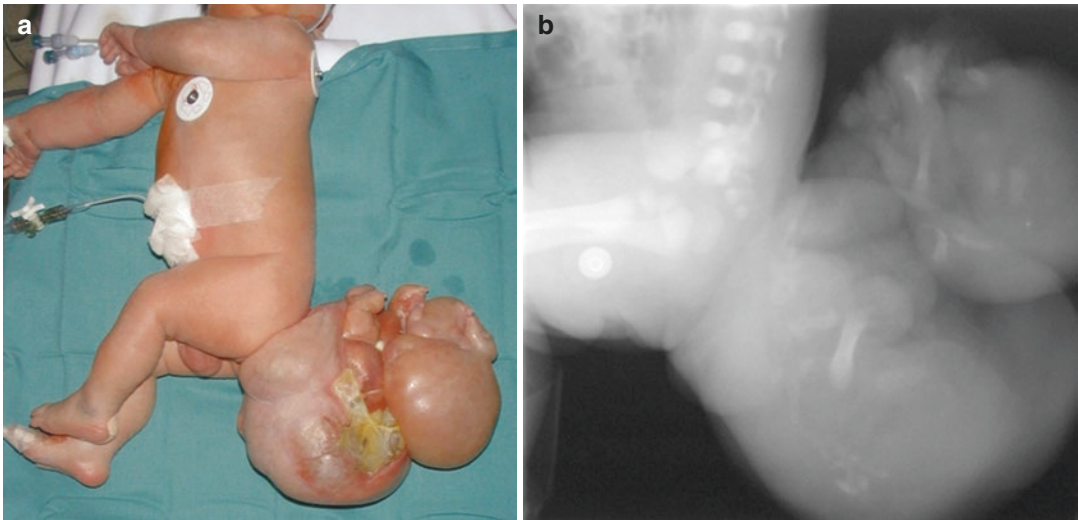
(a, b) SCT Altman III in a female newborn. MRI performed on Day 2
